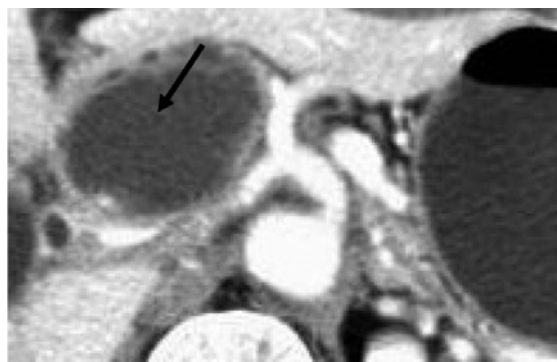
CT scan of a 63-year-old patient with poorly-differentiated pancreatic adenocarcinoma at pancreatic head shows a well-defined cystic tumor (arrowed).
